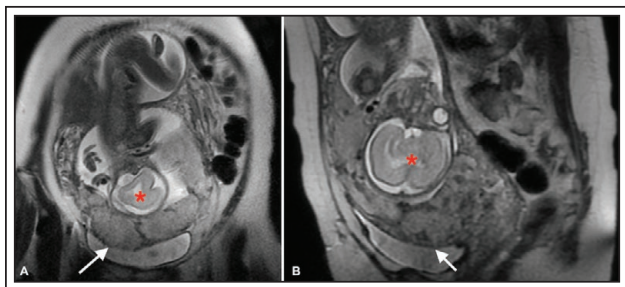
Multiparametric magnetic resonance (MR) imaging of placenta. Fetal head designated with star. (A) Coronal T2-weighted image showing focal bulge of placenta towards bladder with thinning of vesicouterine interface (arrow). (B) Sagittal T2-weighted image again showing findings of invasive placentation (arrow).
